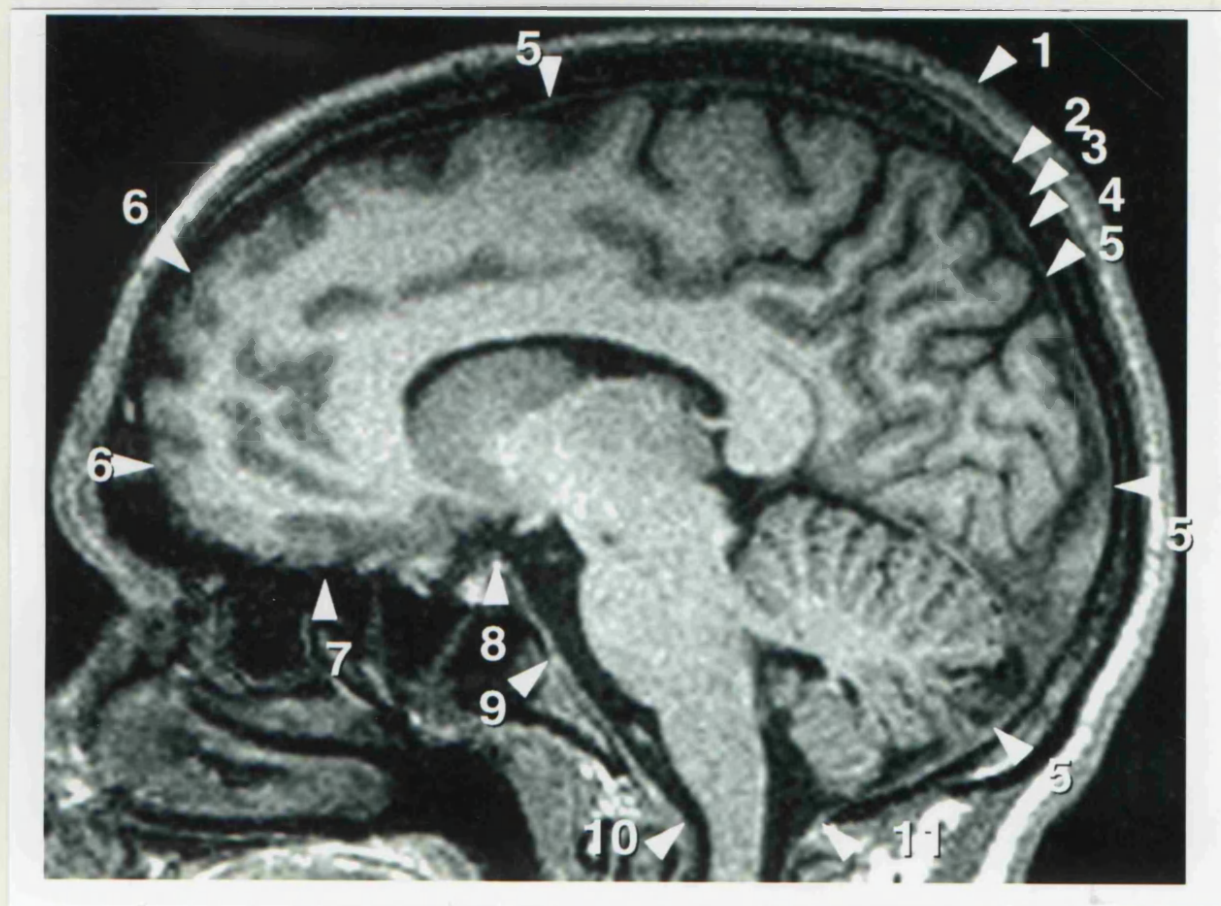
Landmarks for ICV measurement. ICV was measured on the unreformatted 1.25 mm sagittal sections of the MPRAGE. Over the cerebral convexity, the dura mater was used as landmark. The dura is easily visible on thin T1-weighted images as a white line (5). The scalp (1) is visible as a bright white line. The outer table of the skull (2) is seen as a black line immediately below the scalp. The diploë (3) is the white line between outer table (2) and inner table (4), the second black line, of the skull. The dura mater (5) lies immediately below the inner table (4). Over the frontal convexity, the dura may be difficult to visualize, in which case the cerebral contour is outlined (6). Caudally, the undersurfaces of frontal lobe (7), and temporal lobe (not shown) are used as landmarks. The petrous bone is excluded from the measurements (not shown). Other landmarks are the dorsum sellae (8), clivus (9), and at the craniovertebral junction the attachment of the dura to the anterior (10) and posterior arch (11) of C1.
